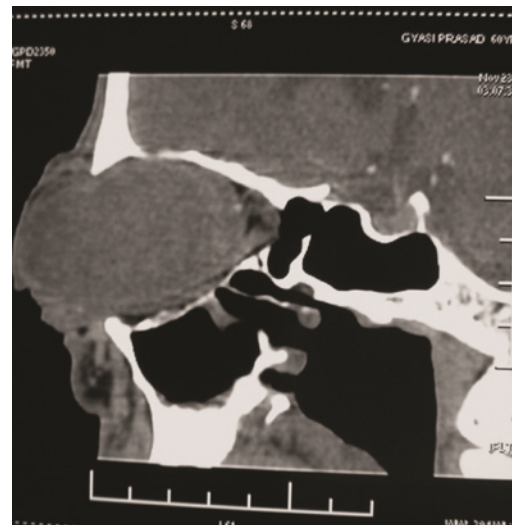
Computed tomography showing a homogenous cystic mass contained within a distended sclera, filling up the entire orbit.
